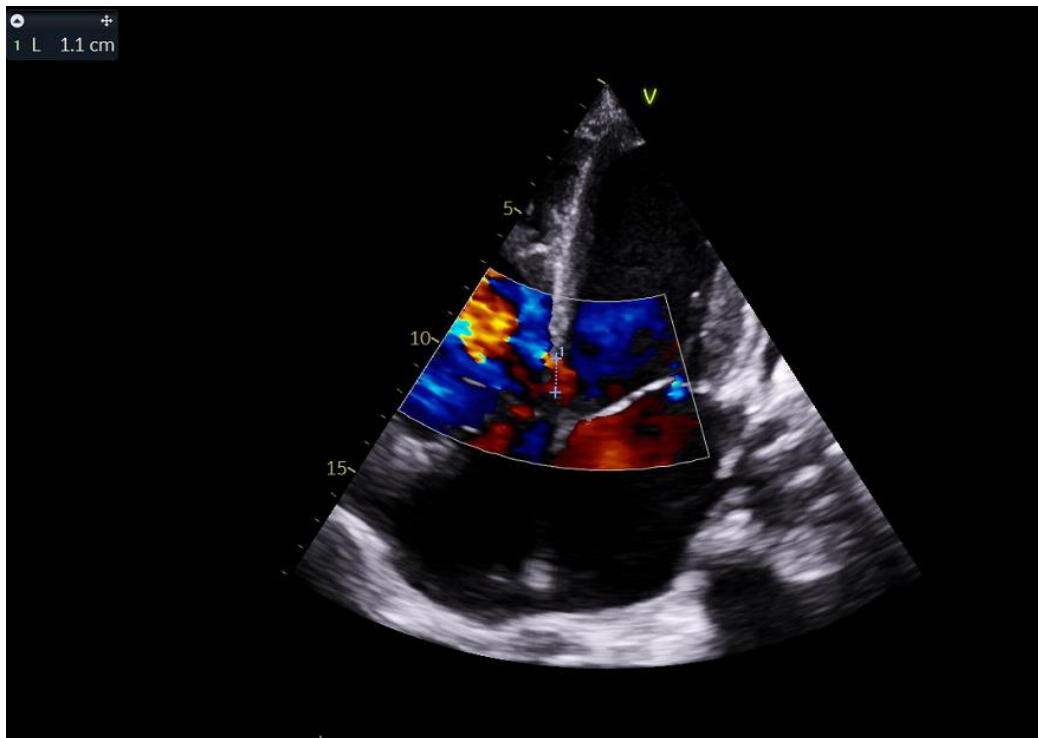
Apical four-cavity cut showing the septal defect (VSD)
